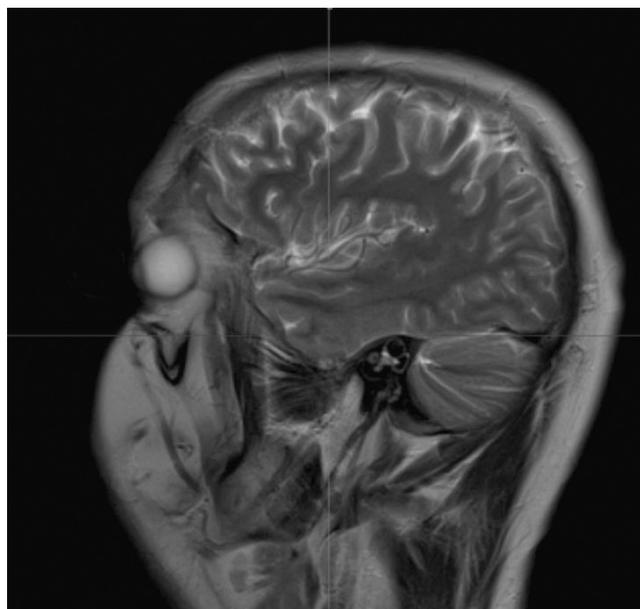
MRI, T2-weighted sequence, sagittal plane. Cerebrospinal fluid decrement in the lateral part of the IAC neighboring the cochlea (corresponding to a meningioma).
